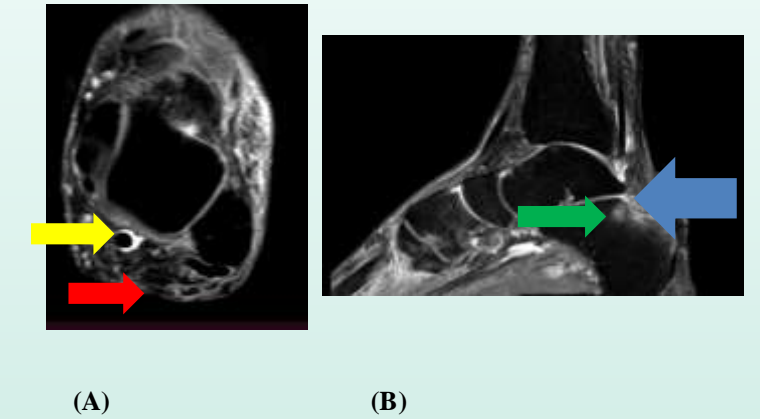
65 years old male patient presented with posterior ankle pain, MRI examination revealed; (A) axial PDW FS sequence showing flexor hallucis longus tenosynovitis (yellow arrow) and marked thinning of Achilles tendon (red arrow), (B) sagittal PDW FS sequence showing stieda process (blue arrow) with subchondral marrow edema of postero-superior aspect of calcaneus (green arrow)
